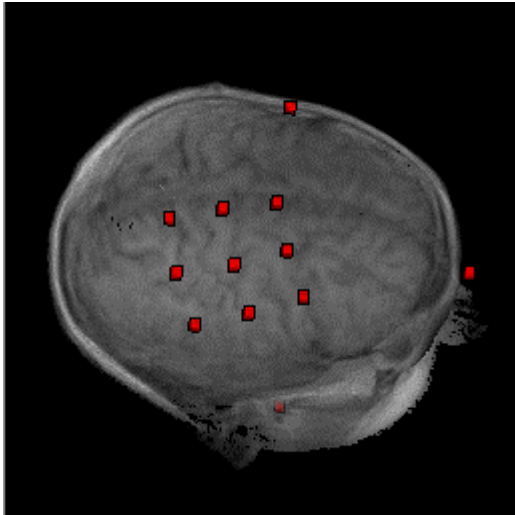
MRI of subject 2, with markers for the positions of the optical fibers in the TMS measurement.
